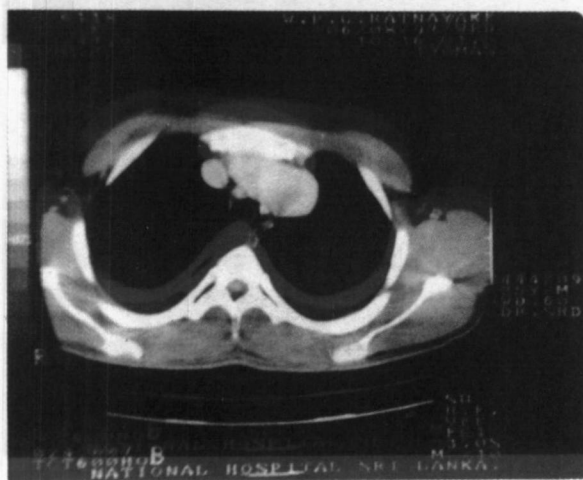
CT scan of thorax showing the anomalous venous connection, dilated superior venacava and vertical vein.
